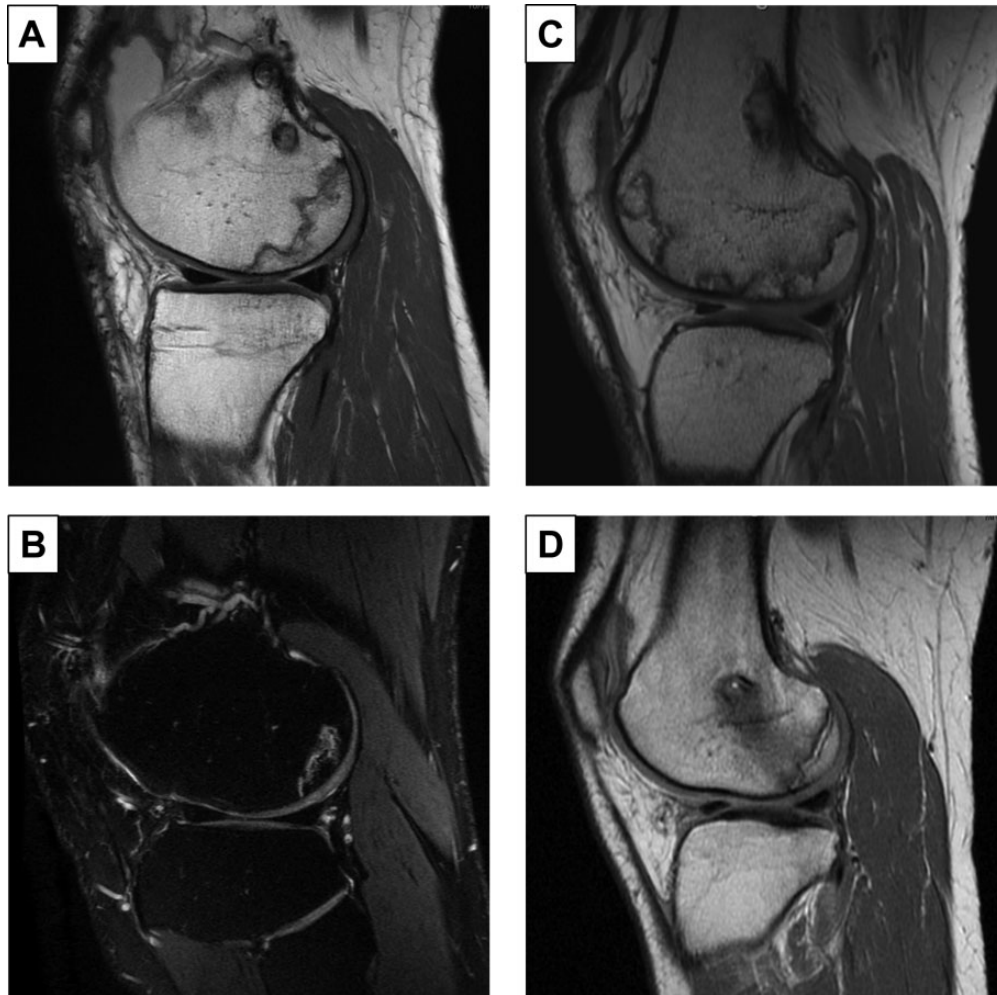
Magnetic resonance images demonstrating osteonecrosis of the lateral compartment of the knee for (A) proton density image of patient 1; (B) fat-saturated, T2-weighted fast spin echo image of patient 2; (C) proton density image of patient 4; and (D) proton density image of patient 5.
